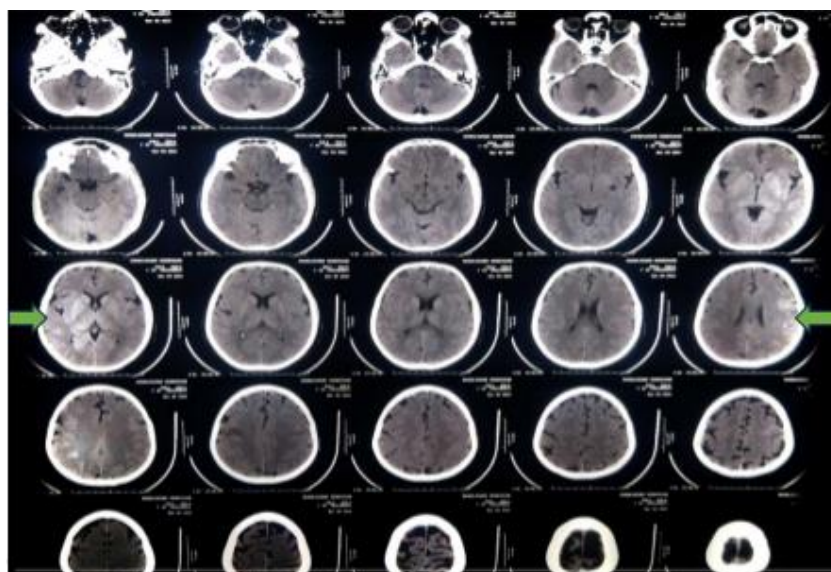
CT brain showing demyelination changes in basal ganglia
